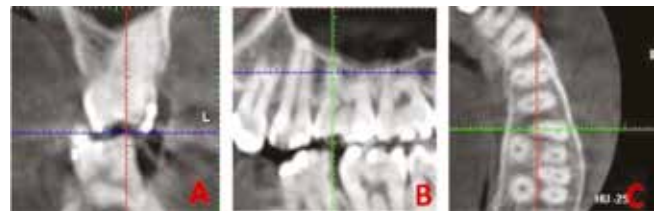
Three views of CBCT image orientation of left maxillary first molar: A, coronal view, with the blue horizontal line being parallel to maxillary first molar occlusal plane; B, sagittal view, with the green vertical reference line along the long axis of mesiobuccal root of maxillary first molar and the functional occlusal plane being parallel to the blue horizontal line; C, axial view, with the green horizontal reference line being superimposed to mesiobuccal root of maxillary first molar.
